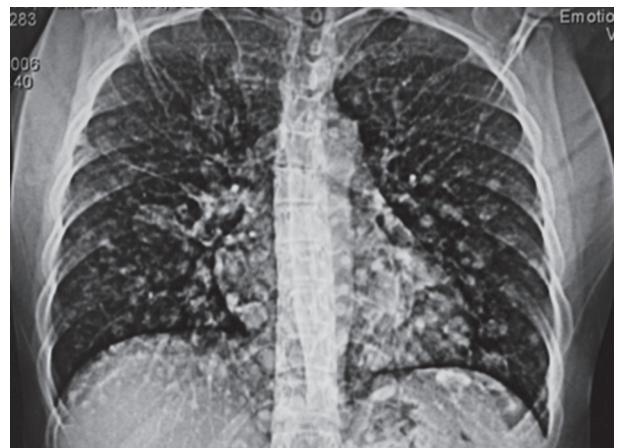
Multiple lung leiomyoma metastasisation pattern in chest x-ray.
